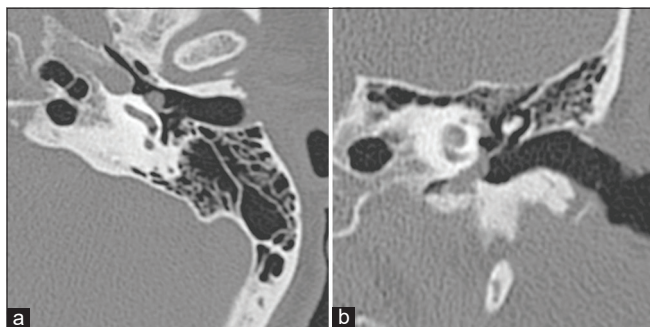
A 39-year-old woman with glomus tympanicum. (a) Axial high-resolution computed tomography and coronal multiplanar reformation image (b) through the middle ear shows presence of a well-defined soft-tissue mass overlying the cochlear promontory (a), and extending into the hypo tympanum.
